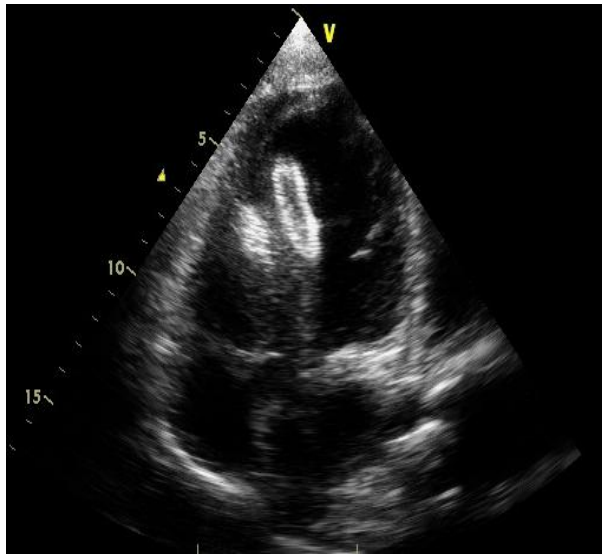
Echocardiography in apical 4 chamber View showing Device in situ
